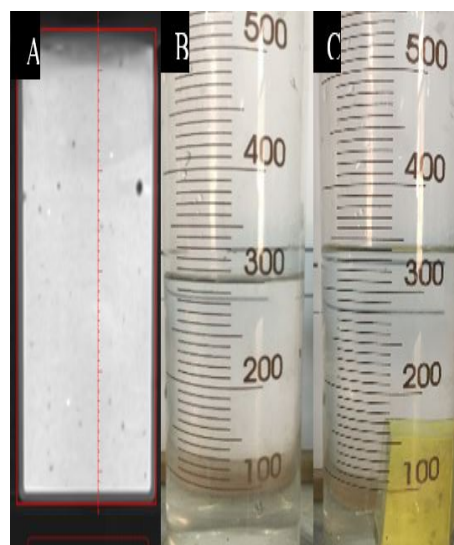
Volumes measured using different methods: (A) radiographic method (B) graduated measuring cylinder without sample (C) graduated measuring cylinder sample.
